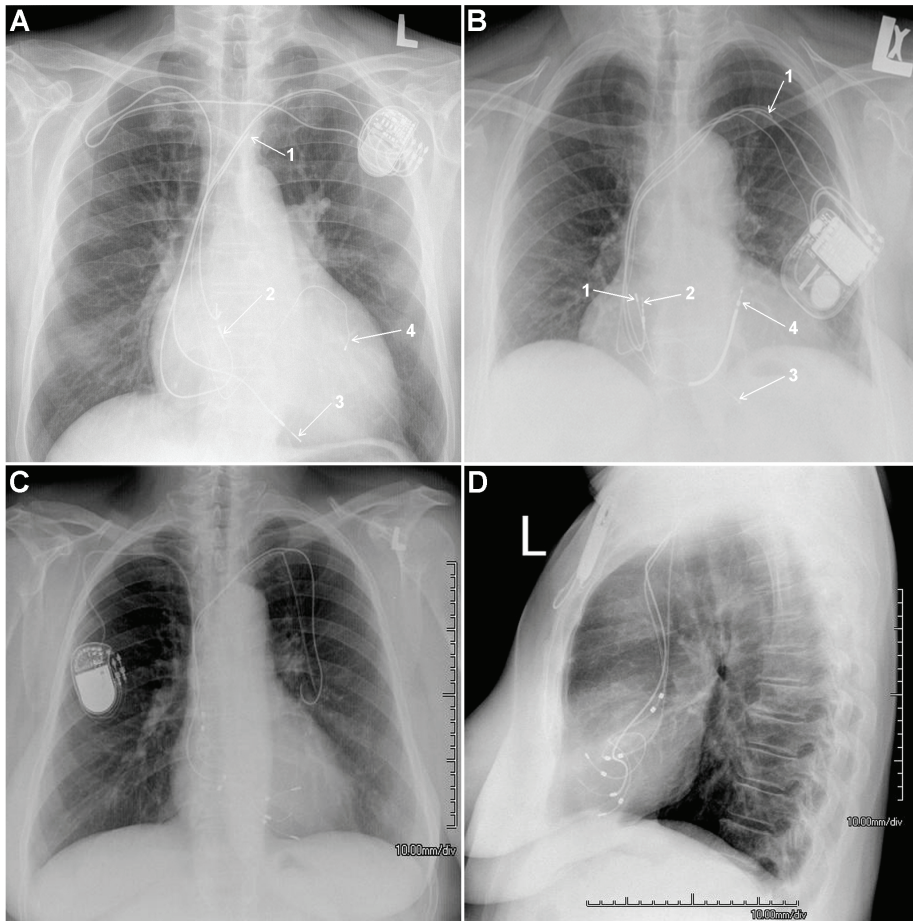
Multiple leads in chest x-ray scan.
